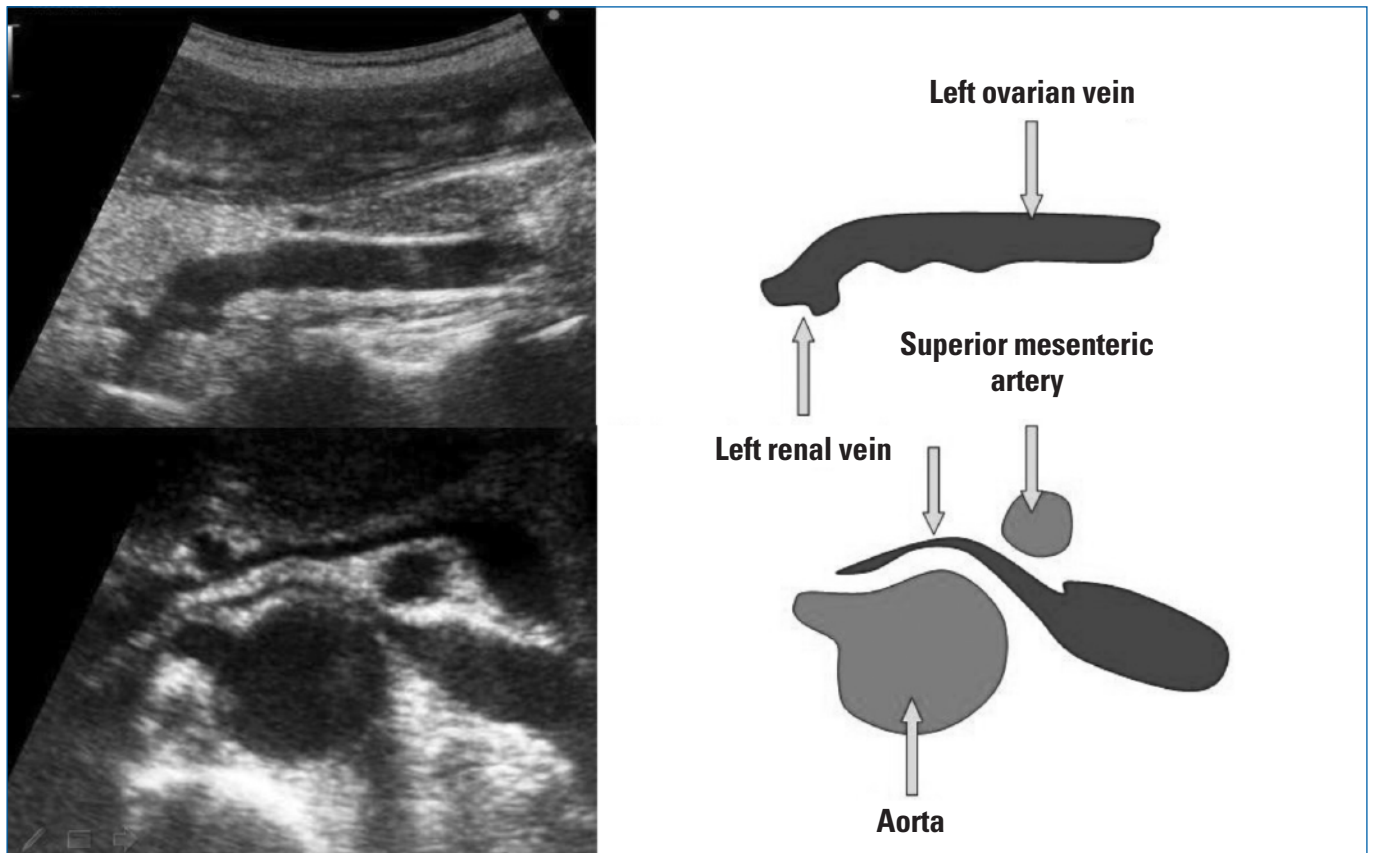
Doppler ultrasonography of pelvic varicosities, upper panel: dilation of the ovarian vein, mesoaortic compression.
